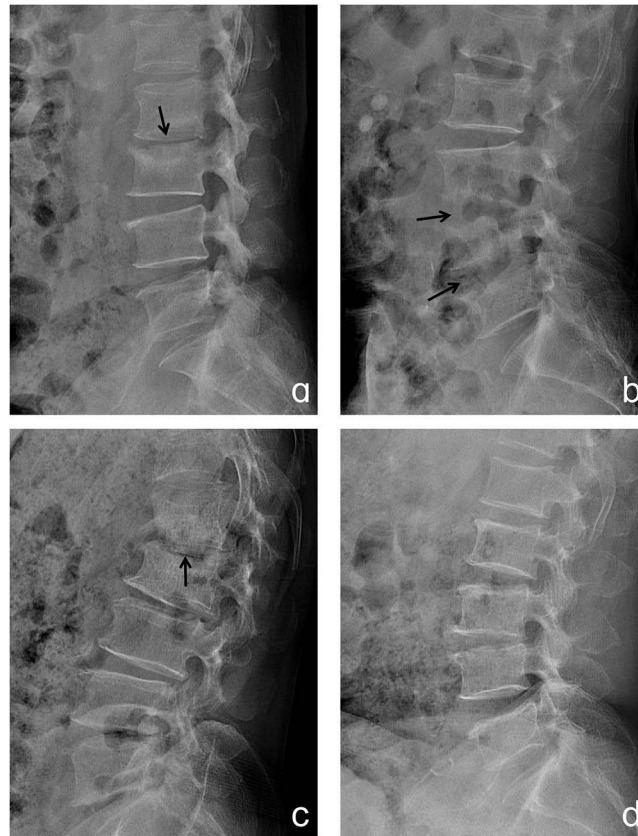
(a) Lumbar X-ray of fungal spondylitis in the lateral view shows L2-3 intervertebral stenosis (black arrow); (b) Lumbar X-ray of fungal spondylitis in the lateral view shows no L3-4 or L4-5 intervertebral stenosis (black arrow); (c) Lumbar X-ray of brucellar spondylitis in the lateral view shows L1-2 intervertebral stenosis (black arrow); (d) Lumbar X-ray of brucellar spondylitis in the lateral view shows no obvious intervertebral stenosis.
